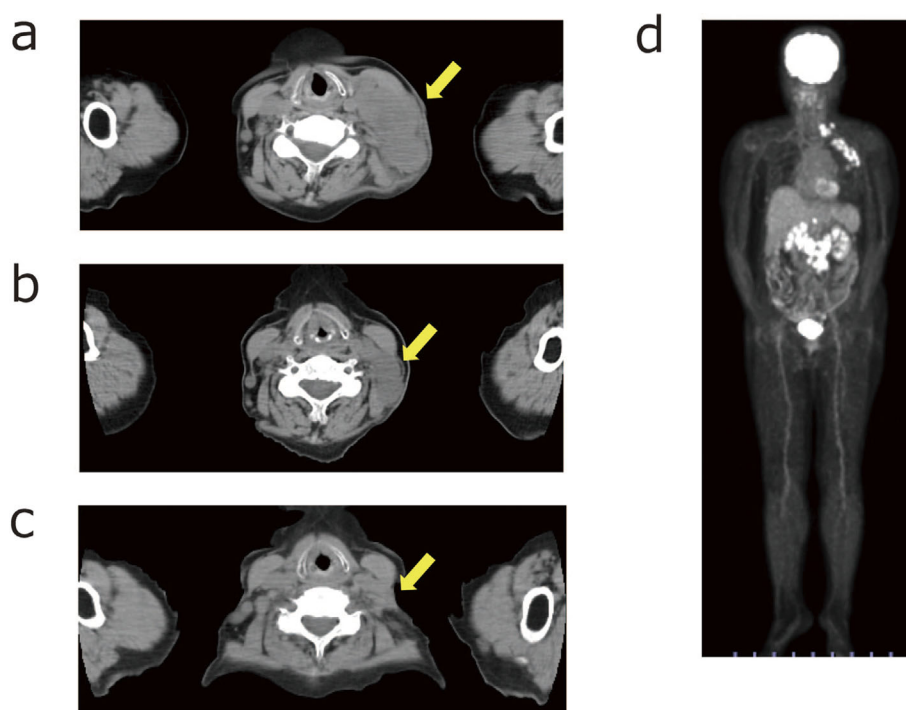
Comparison of computed tomography scans of the left cervical lymph nodes before and after treatment. The pretreatment lesion (a, yellow arrow) appears substantially reduced one month after commencing capmatinib therapy (b, yellow arrow). A remarkable reduction was observed in March 2024, as indicated by the yellow arrow in (c). PET-CT from January 2023 prior to treatment showed lymph node enlargement with abnormal fluorodeoxyglucose (FDG) radiotracer accumulation in the left axillary, supraclavicular, neck, and abdominal regions. No other abnormal organ-specific FDG uptake was observed (d). PET-CT: positron emission tomography-computed tomography
